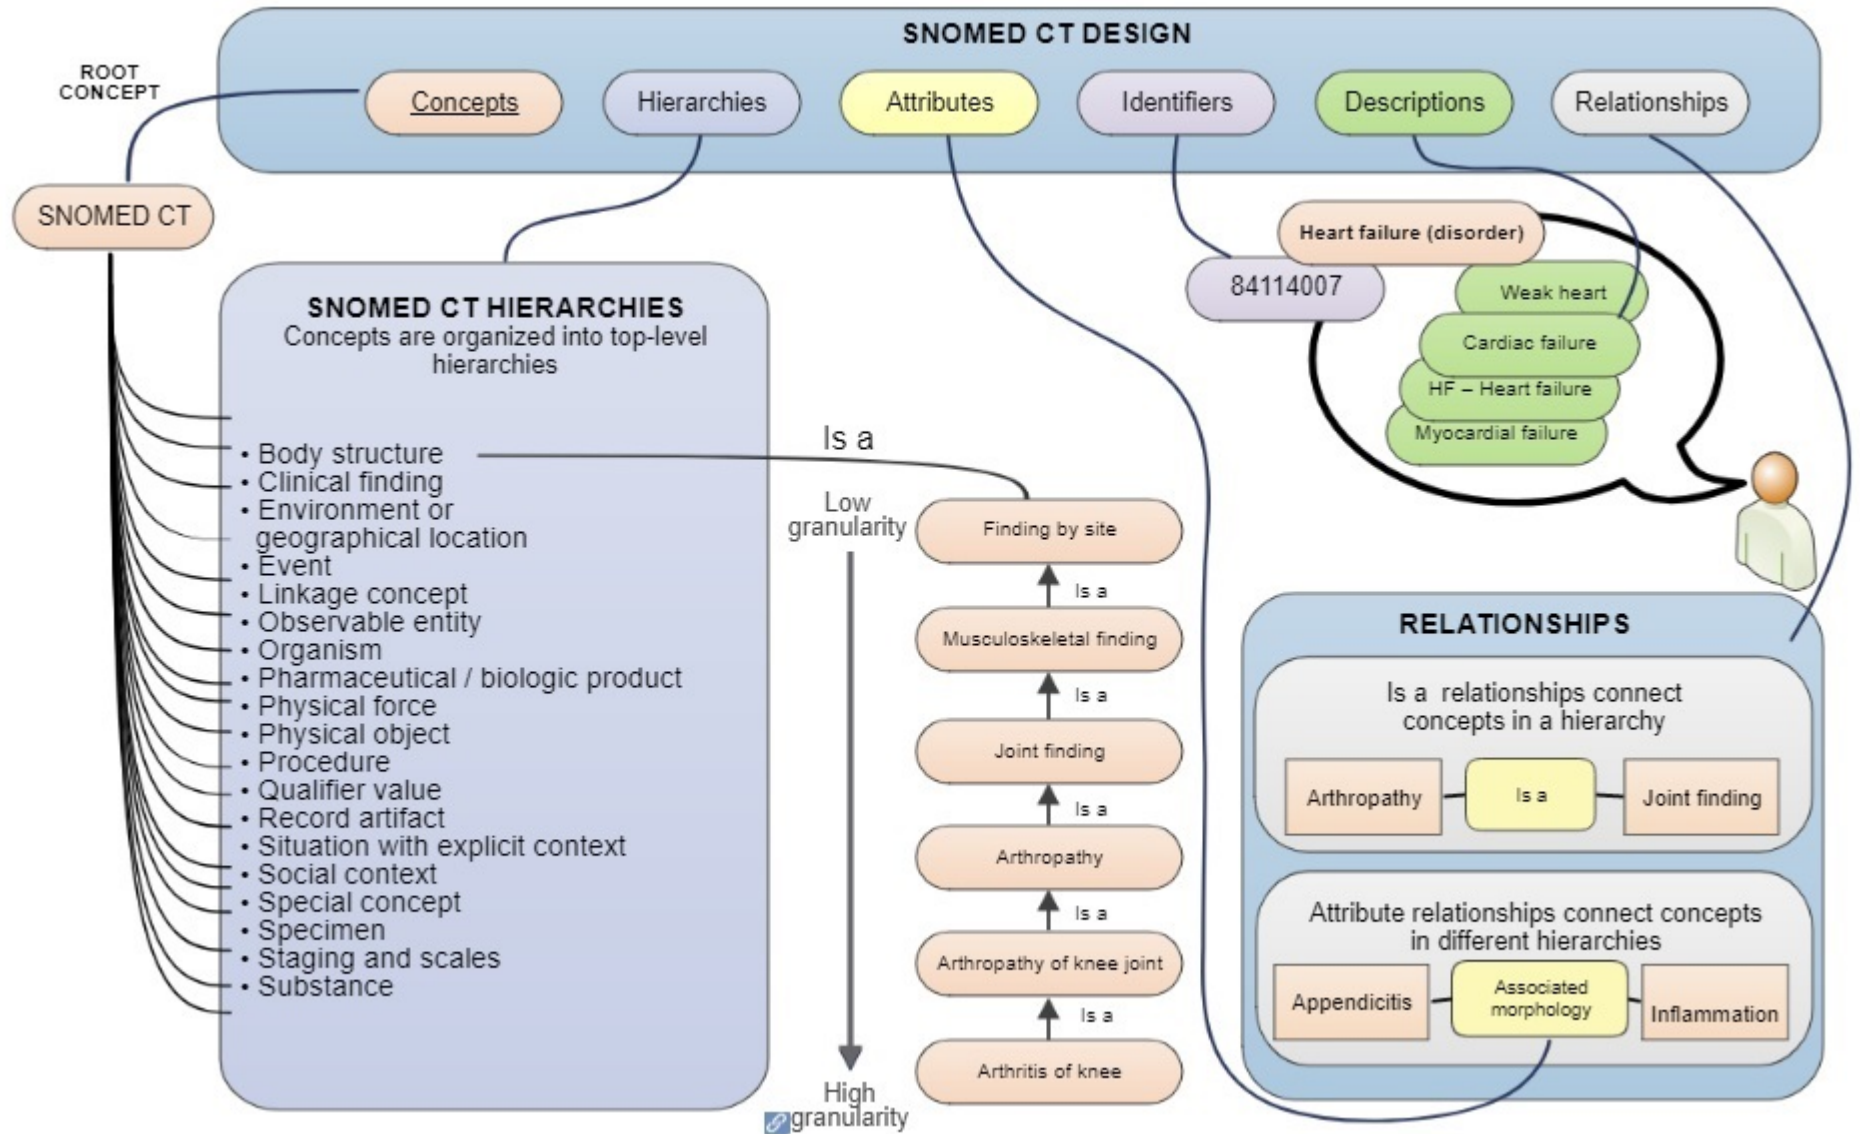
SNOMED CT Design from taken main page of SNOMED International (2018).
